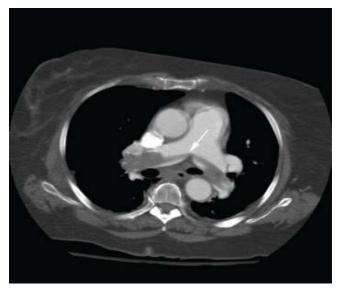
Chest CT scan shows Saddle Pulmonary Embolism (white arrow) in a Patient with SAH (*Kurtz et al, 2010*)
